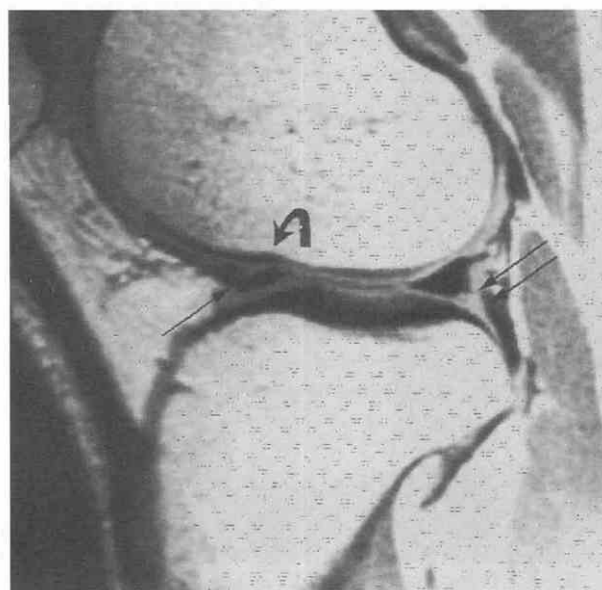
Popliteus tendon sagittal view. Sagittal T1-weighted image shows the normal high signal intensity of the popliteus tendon sheath at the posterior horn of the lateral meniscus (double arrow). Also, note the transverse ligament attachment to the anterior horn of the lateral meniscus. The plane between them should not be mistaken for a tear (arrow). The normal indentation of the lateral condylar surface representing the junction of its tibial and patellar articular surfaces should not be confused with an osteochondral fracture. The cartilage and subchondral cortex are intact (curved arrow).
